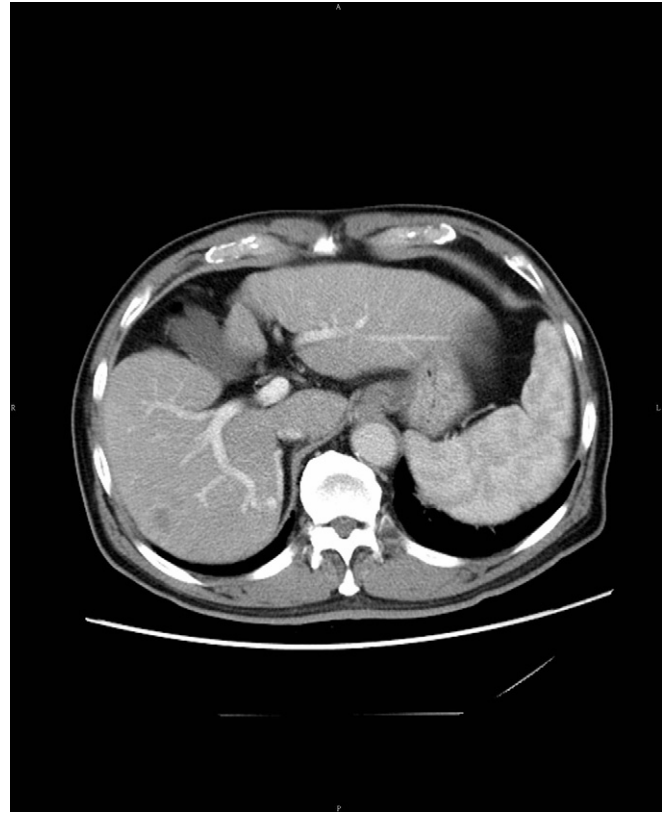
CT scan of case 2 showed a solitary mass ($3 \times 2.5 \times 1 \text{ cm}^3$) with irregular margin in segment 6 of liver, with a peripheral enhancement pattern and central area of necrosis. CT = computed tomography.
